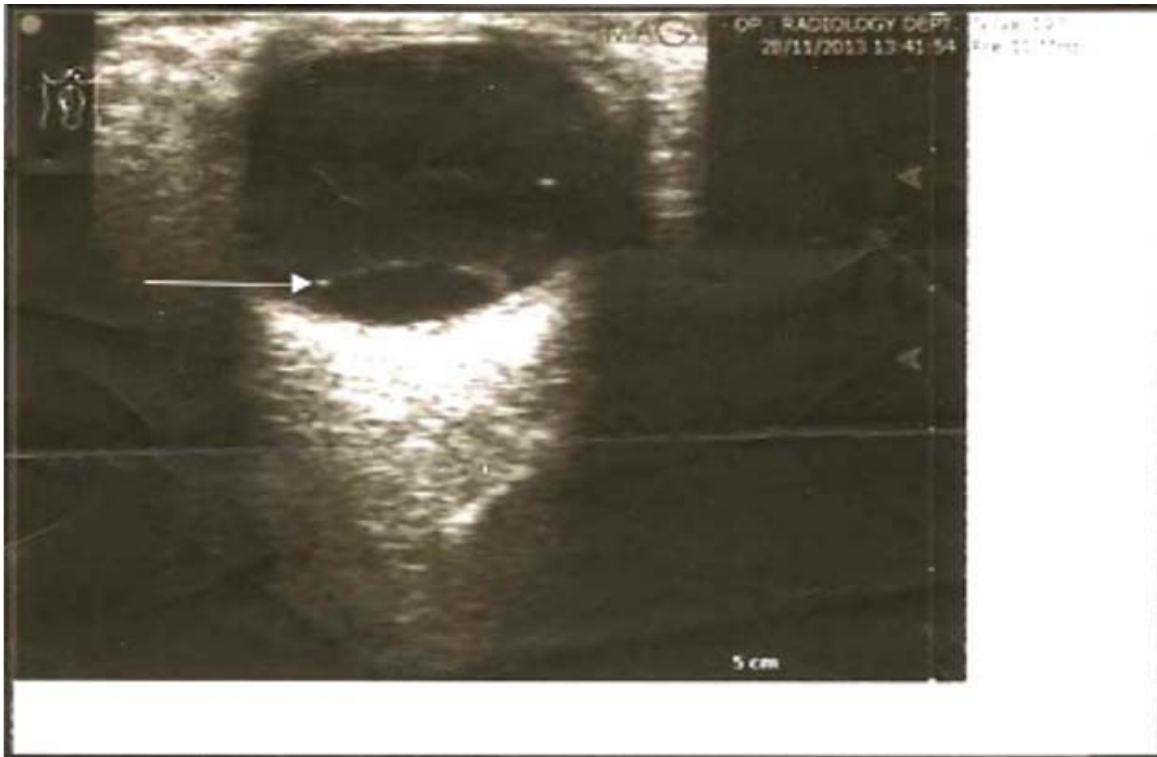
Transverse ultrasound image showing choroidal detachment (arrow)
